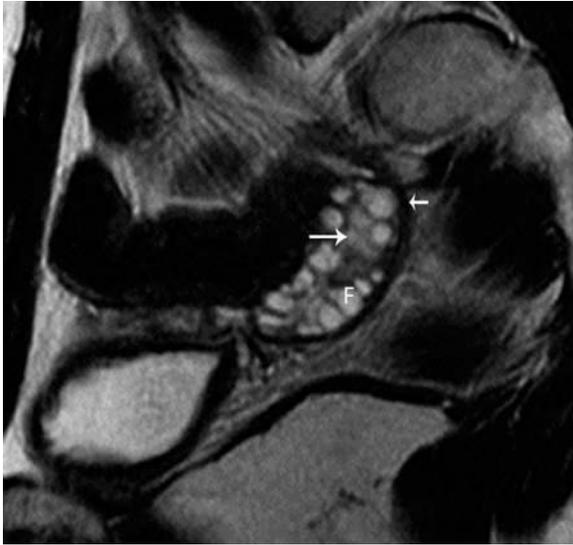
Normal ovary in a 27-year-old female. Sagittal T2-weighted image depicts the normal anatomy of the ovary with a low T2 signal intensity cortex (short arrow), higher T2 signal intensity medulla (long arrow), and multiple high T2 signal intensity and subcentimeter peripheral follicles (F).
